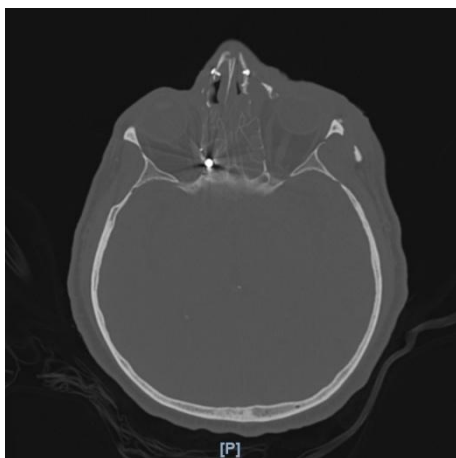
Axial computed tomography (CT) scan of the skull. A shotgun bullet is observed stuck in the region of the posterior ethmoids, located in close proximity to the medial wall of the orbit and optic nerve.
